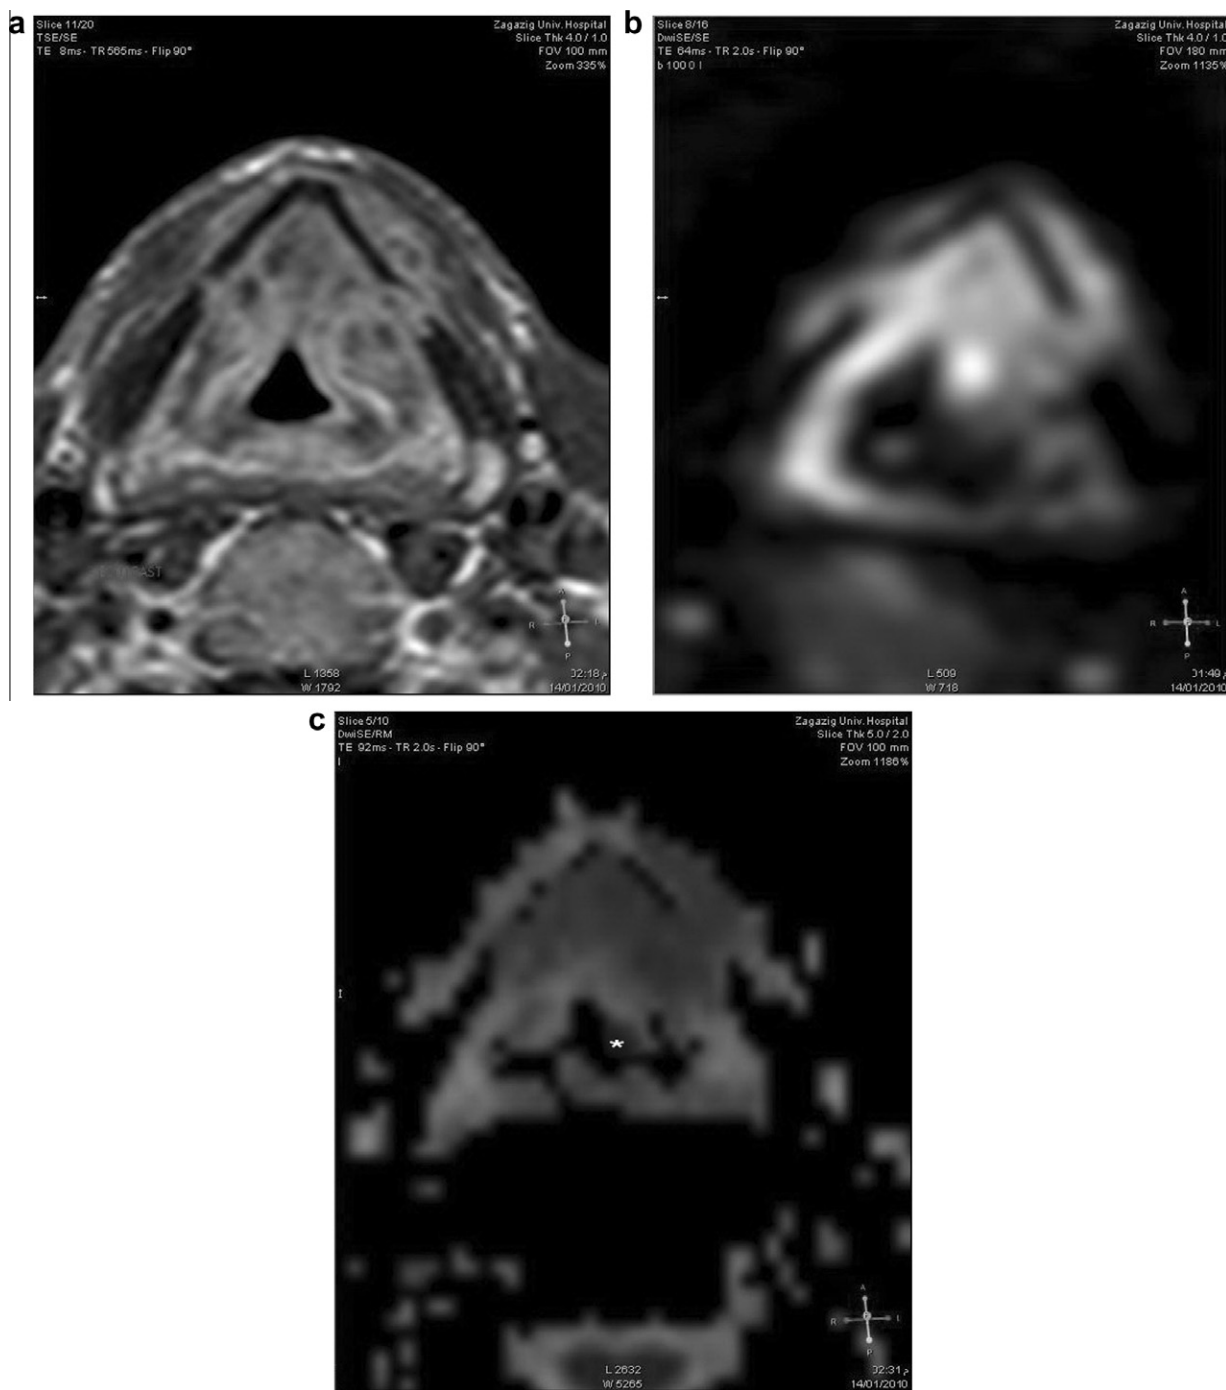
Axial contrast enhanced T1 weighted MR image shows heterogeneously enhanced lesion involving the glottis region more on the left side of the larynx (a). At DWI b 1000 (b) the lesion displays high signal intensity however it shows low signal intensity (*) at ADC map (c). This lesion was proved pathologically to be recurrence.
